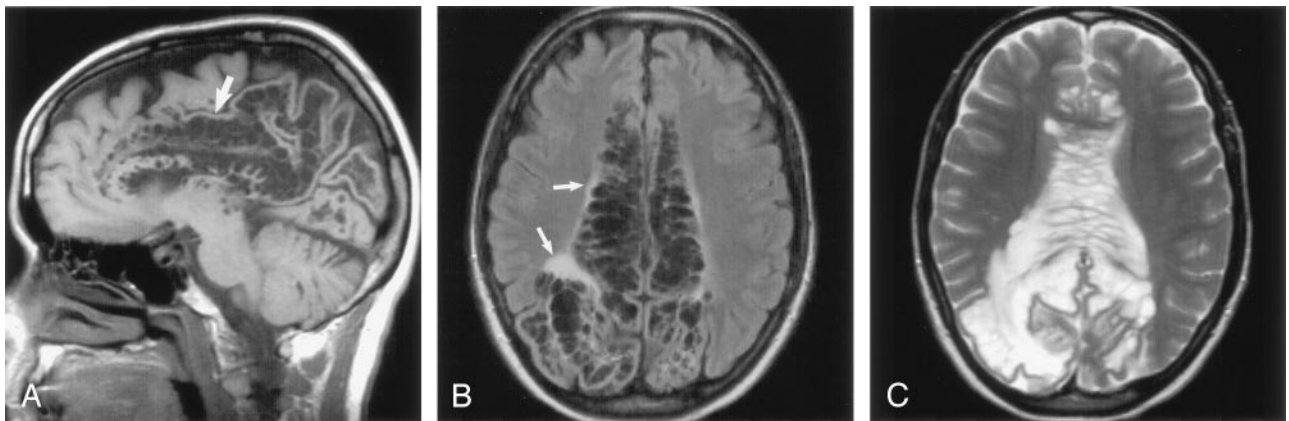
Sagittal T1-weighted (A), axial FLAIR (B), and axial T2-weighted (C) images obtained in a 46-year-old woman with a visual field defect show extensive involvement of the corpus callosum and cingulate gyrus (A, white arrow) with extension to the subcortical white matter of the parietal and occipital lobes. There is slight increased signal intensity surrounding the lesions, best seen on FLAIR image (B, white arrows). The gray matter is stretched and displaced over the multiloculated giant perivascular spaces. Case courtesy of Leena Valanne, MD.
